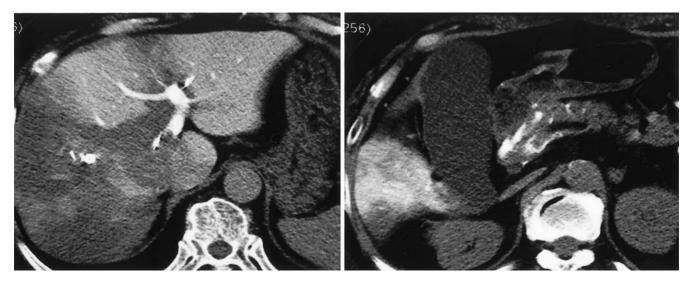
Computed tomography during arterial portography, performed 17 days after thrombolytic therapy. Portal flow has partly recovered through collateral vessels in the pancreatic head and hepatoduodenal ligament
